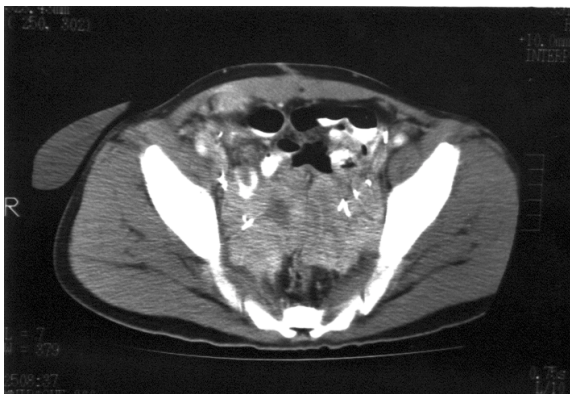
Enhanced CT taken at the level of the mid-pelvis shows a large recurrent lobulated heterogeneous tumour occupying most of the pelvic cavity.
